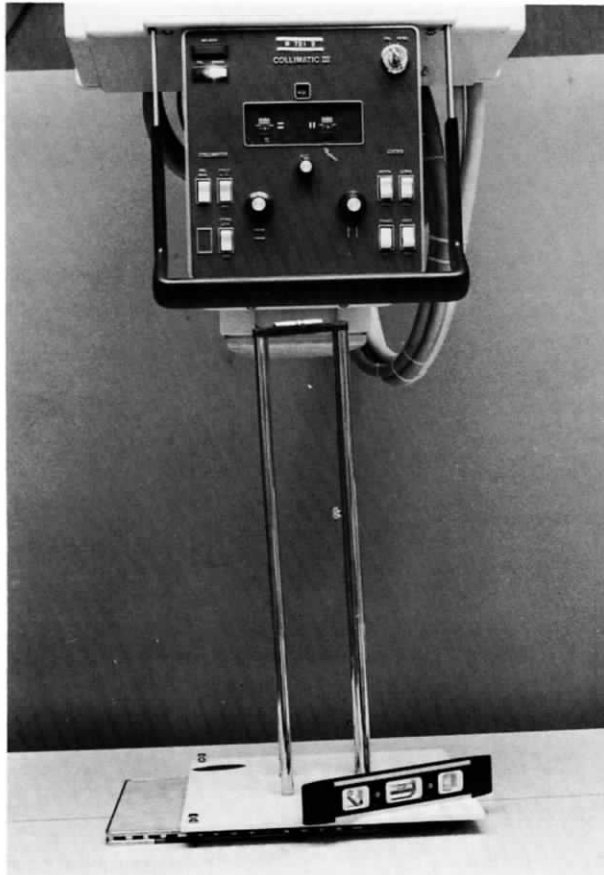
X-ray tube focal spot size pinhole measurement test setup. The pinhole camera top plate, containing the pinhole, should be leveled, as has not yet been done in this figure. With the appropriate modifications an extremity cassette may be slid under the camera and multiple exposures can be made on one film.
